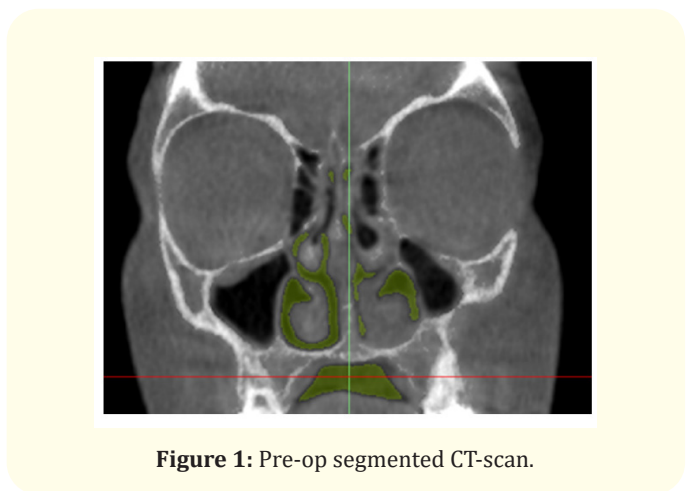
Pre-op segmented CT-scan.
